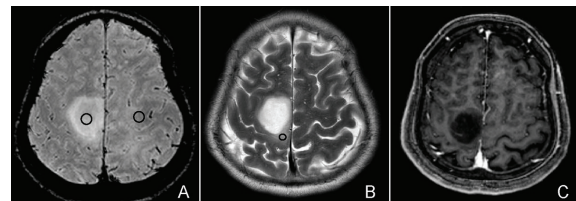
Non-enhancing tumor (oligodendroglioma WHO II) at right frontal parietal region. (A) FLAIR shows ROI of solid tumoral region (right circle) and NAWM (left circle). (B) T2W shows ROI of peritumoral edema (circle). (C) Gd-T1W shows no enhancement of the mass.
